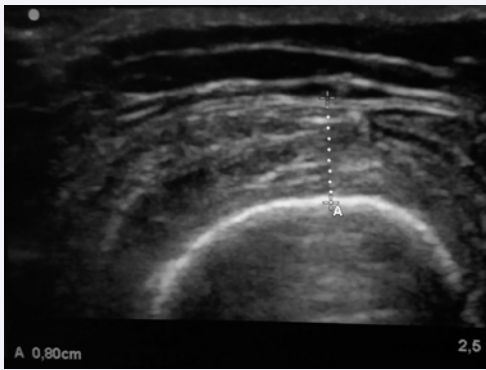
Quadriceps ultrasound at ICU admission of case 2.
